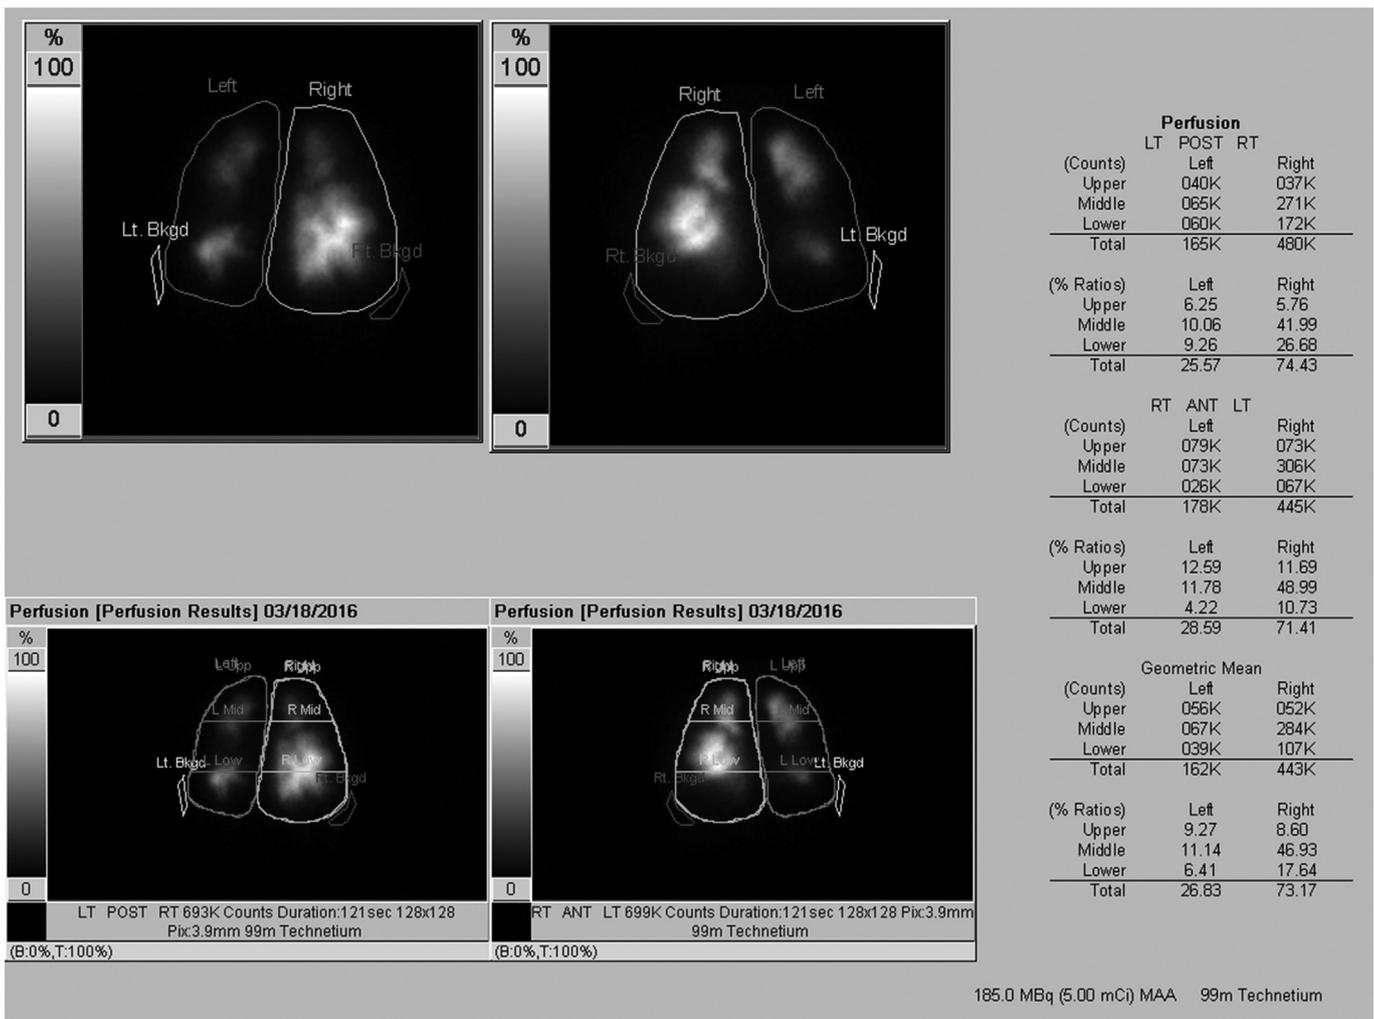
33 y/o female with cystic fibrosis being considered for lung transplant. Lung scintigraphy shows bilateral reduction of perfusion to the left lung and to the upper right lung. The differential perfusion is 27% to the left lung and 73% to the right lung. These large differential perfusion has been shown to correlate with increased risk of death of these patients while on the transplant list.
